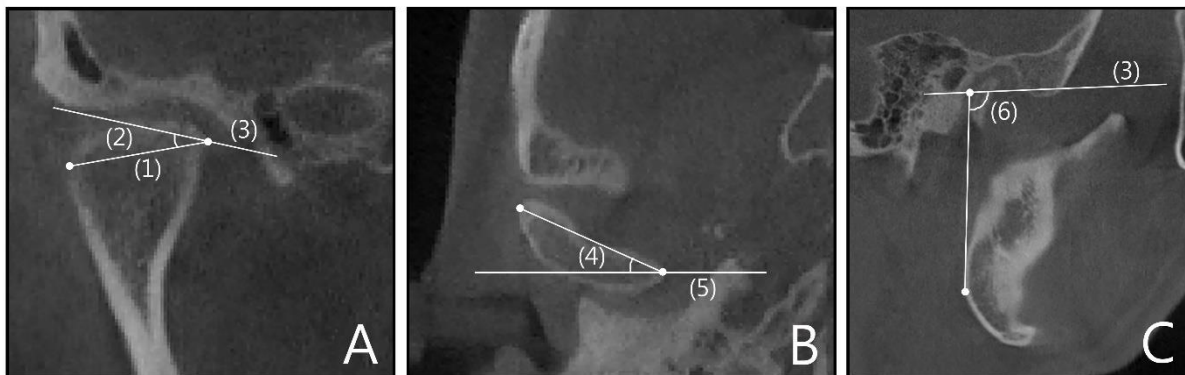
Measurements of TMJ in 2D CBCT images (A. coronal view, B. horizontal view, C. sagittal view, (1). CCW, (2). CCA, (3). Frankfort Plane, (4). HCA, (5). Right-Left line, (6). SRA)
